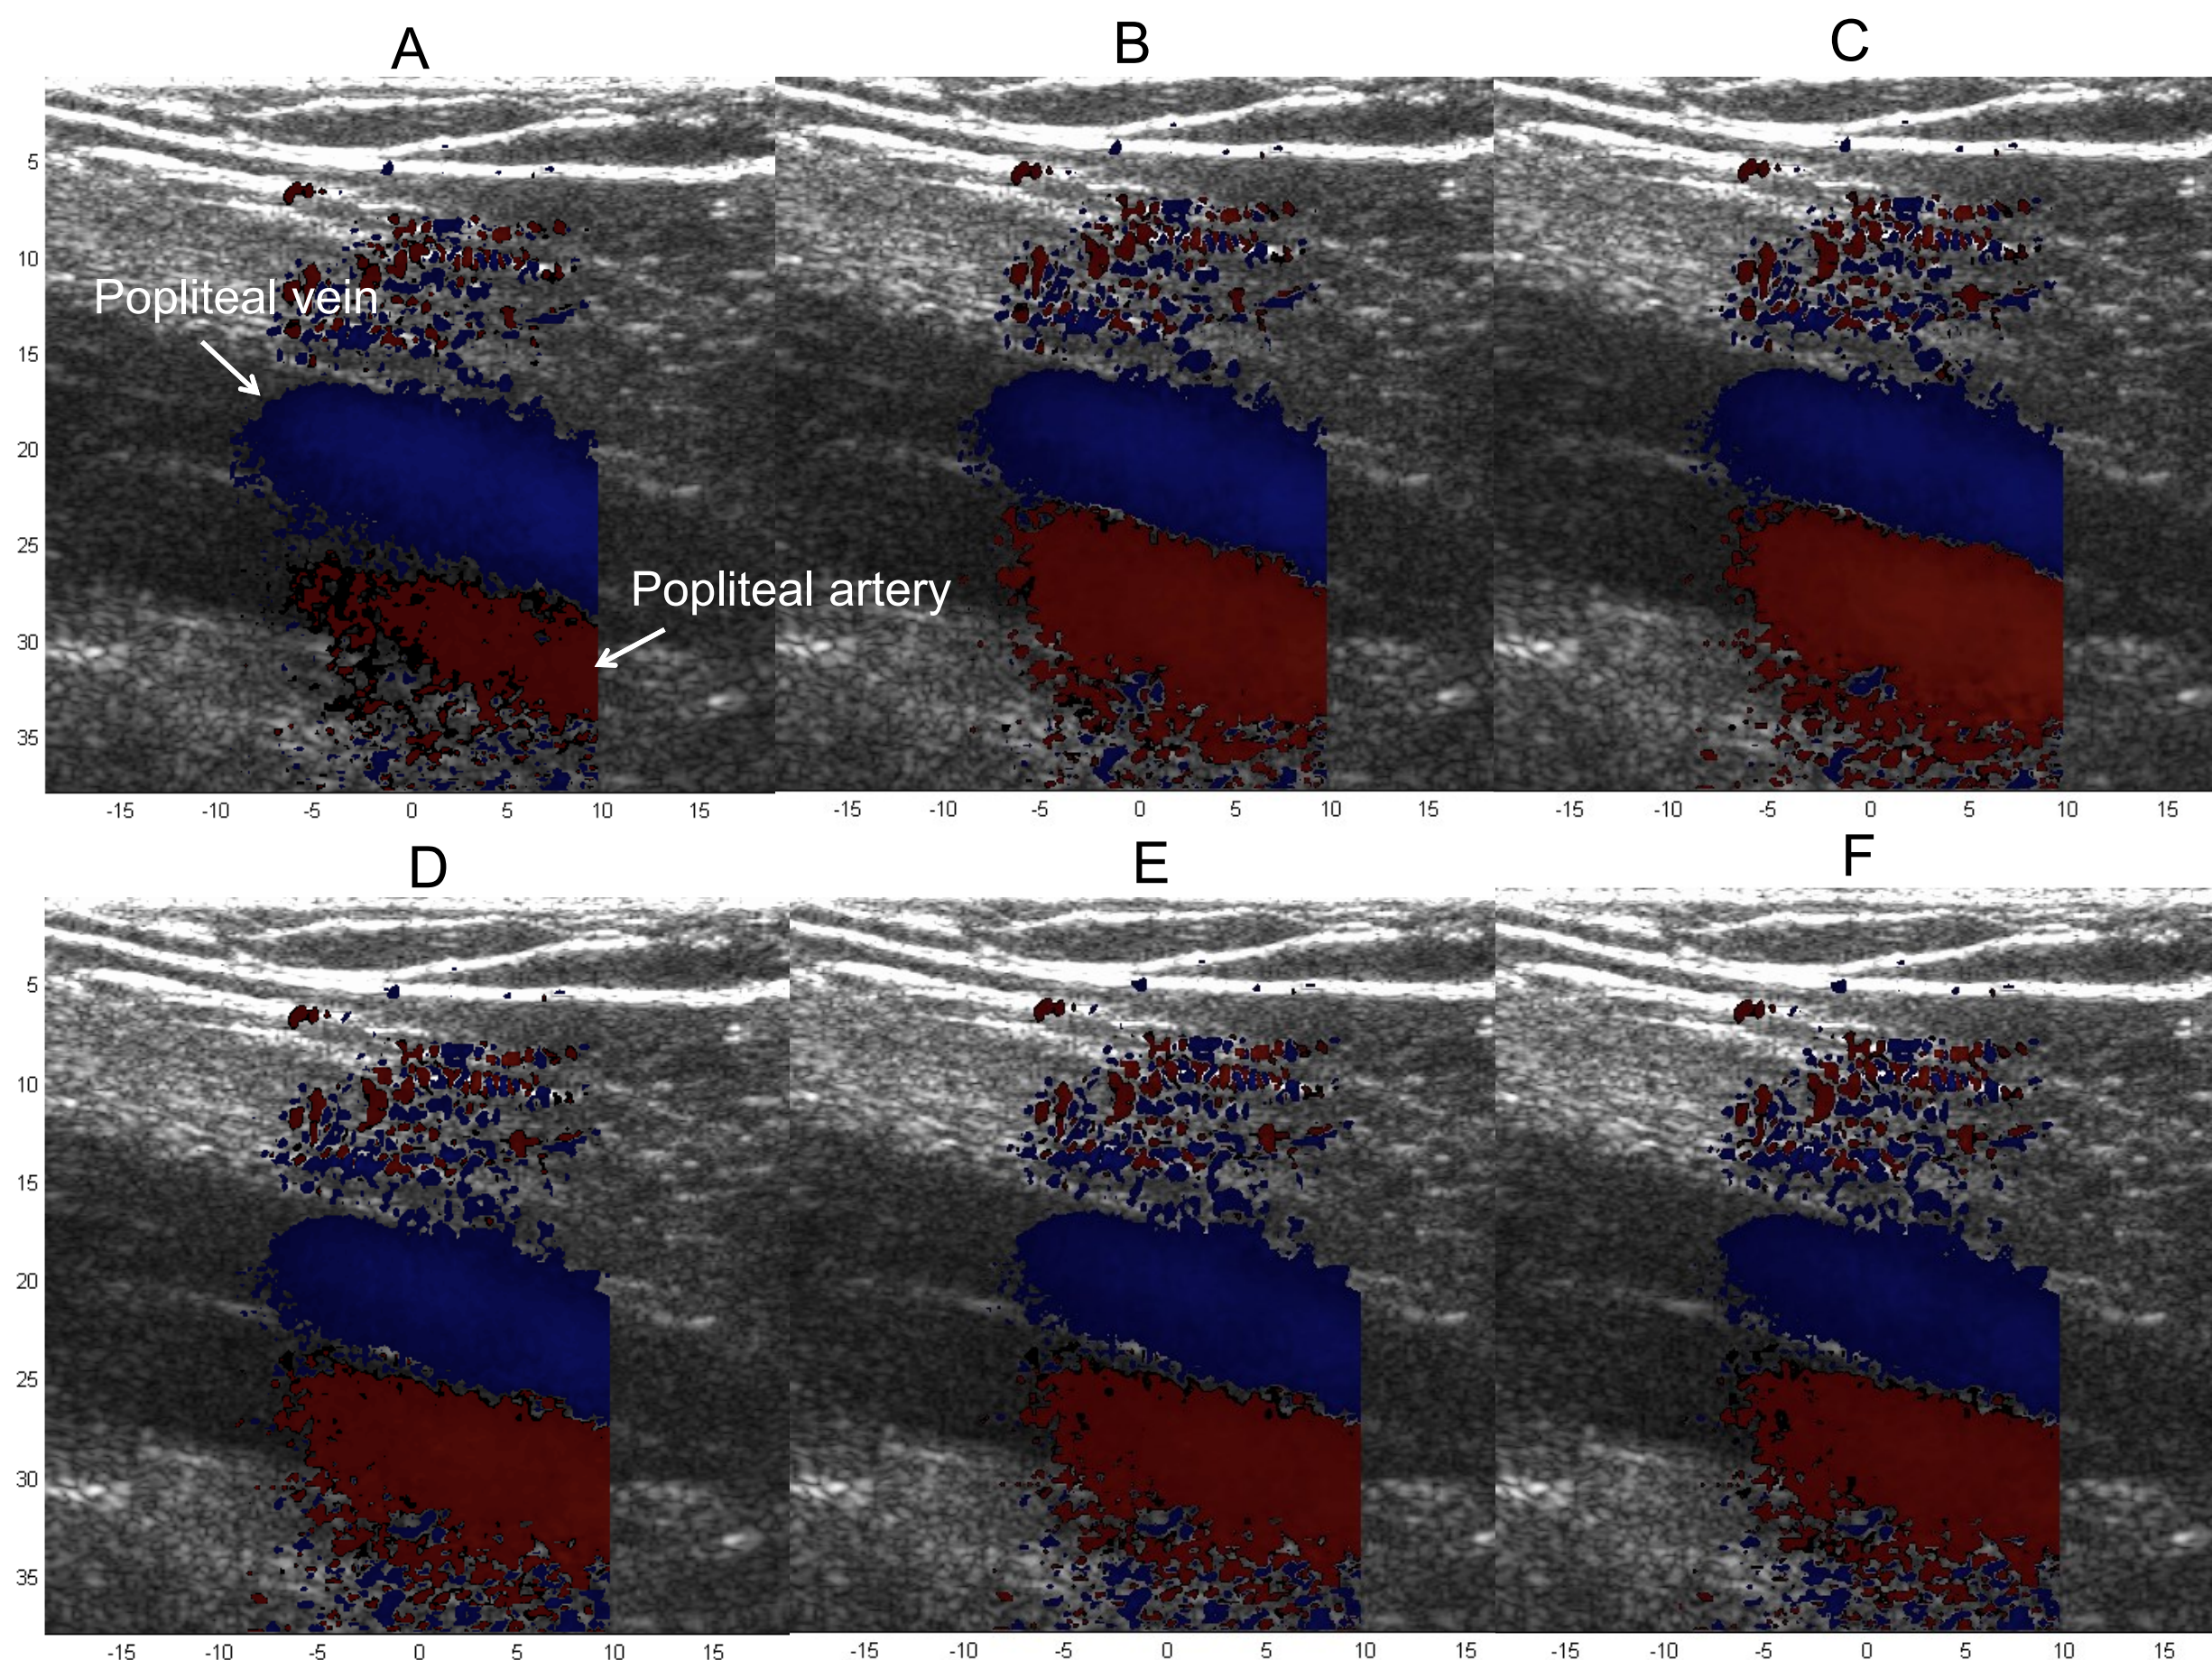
Six consecutive frames of color Doppler ultrasound data (A-F) depicting blood flow through the popliteal artery and popliteal vein during a single heartbeat. Blue color signifies blood flow moving up towards the transducer, or a vein, whereas red color signifies blood flow moving down away from the transducer, or an artery.
